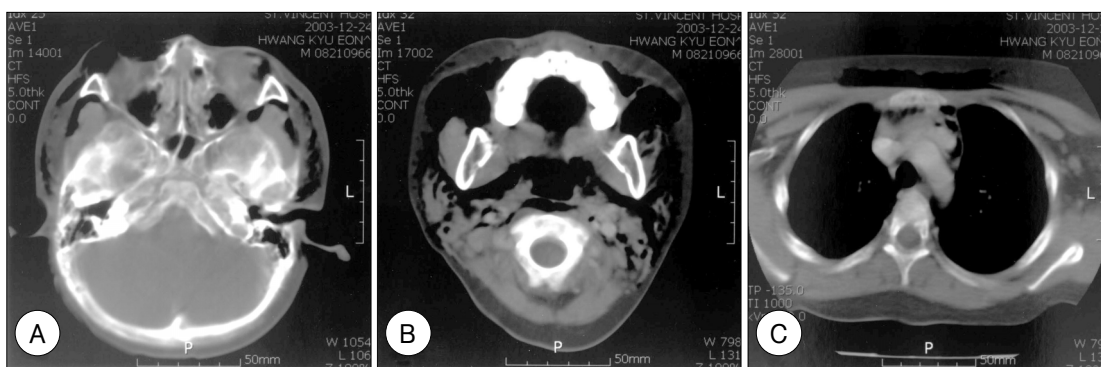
Three computed tomography scans at the nasal bone level (A), the parapharyngeal and tonsil level (B), and the carina level (C). (A) shows that air involvement extended up to the eye lids and the temporal space and (B) shows that subcutaneous emphysema involved the parapharyngeal space, retropharyngeal and buccal space and (C) shows that air bubble extended down to the mediastinum and the anterior chest.
